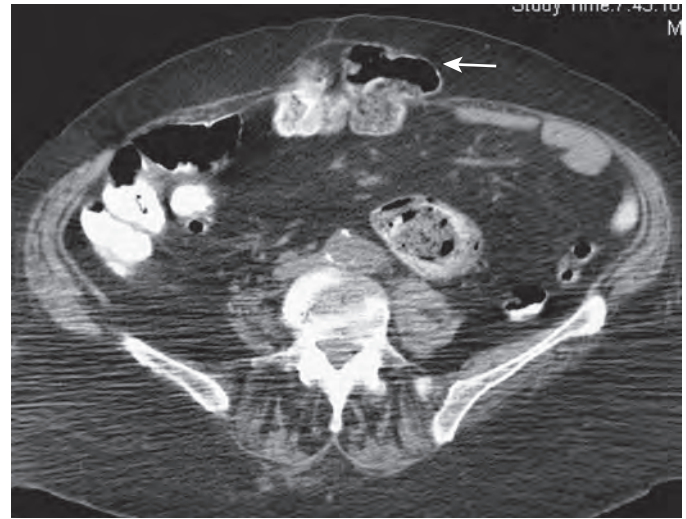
Incisional hernia. The CT scan performed 1 year after laparotomy shows a knuckle of transverse colon (arrow) protruding beneath a healed midline incision.
